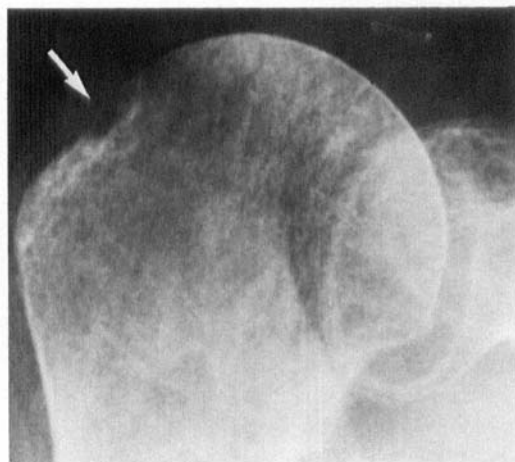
Preoperative radiograph of the right shoulder of a 68-year-old woman. Normal joint space, osteoporosis and erosion of the anatomical neck (arrow). Larsen Class II.
